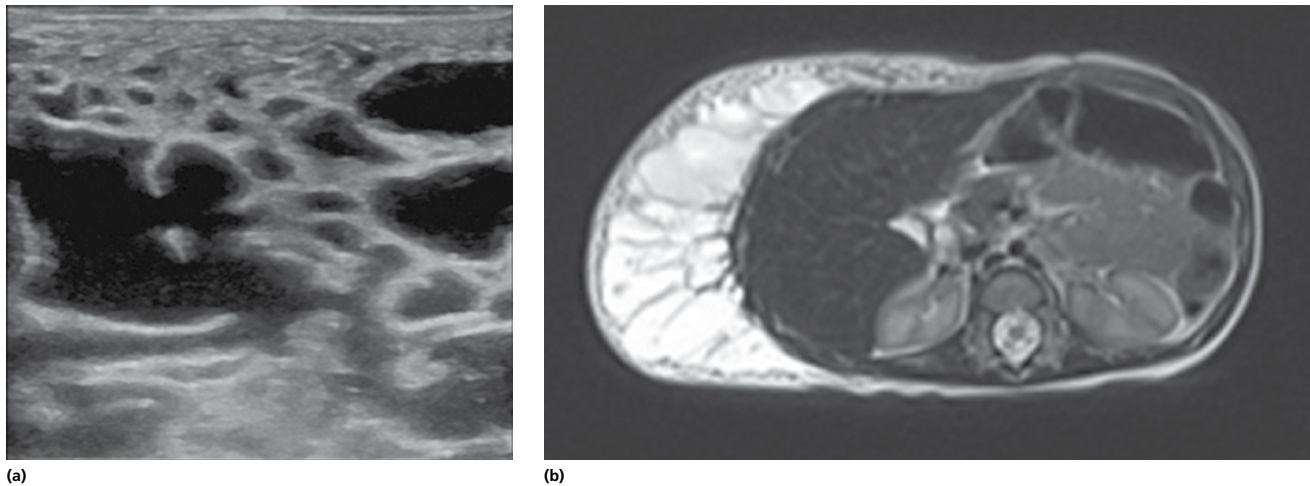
(a) Ultrasound image of the lymphatic malformation of the chest wall in the child shown in Figure 16.5. Cysts of varying sizes can be seen, separated by thin septae. (b) T2-weighted axial MRI image of the same lymphatic malformation. The majority of the macrocysts lie deep to the microcysts.
